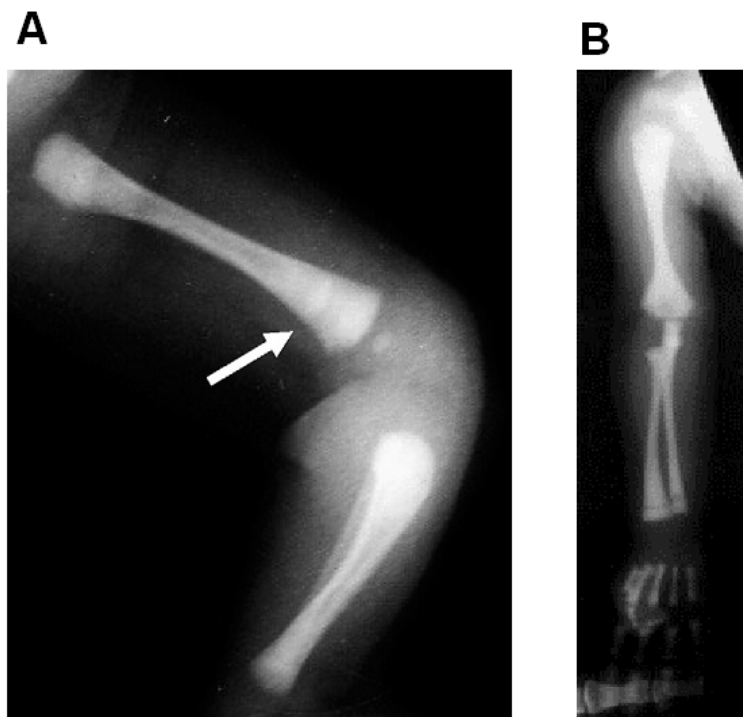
Radiographical examples of osteopetrosis. (A) Severe osteopetrotic femur and tibia. Increased bone density and notable decrease in bone marrow cavity. Arrow indicates funnel like appearance and alternating lucent bands. (B) Osteopetrotic arm with notable “bone in bone” appearance of the metacarpals (Adapted from Fattore et al., 2008, Wilson et al., 2000)
